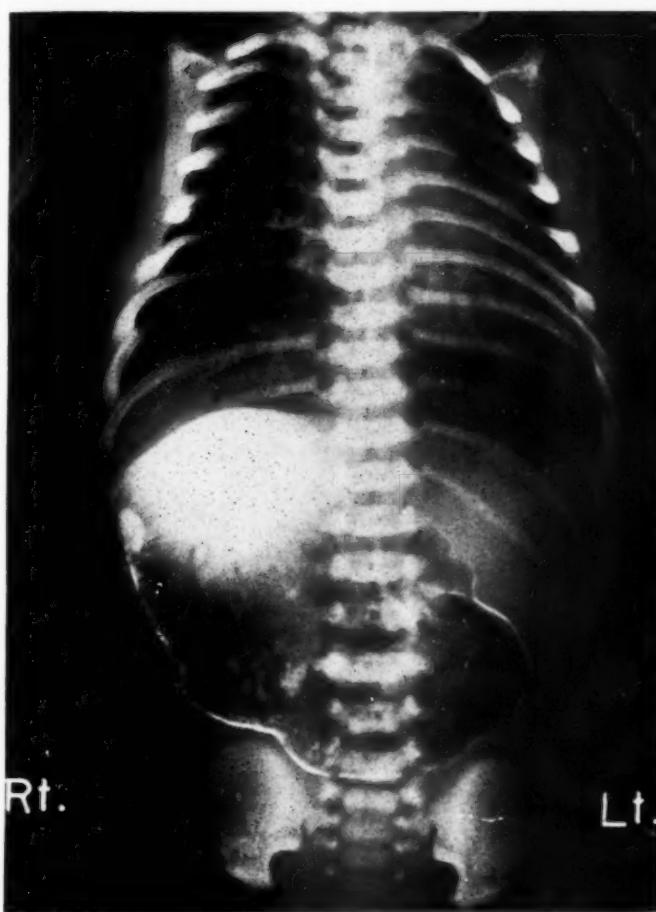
Posteroanterior roentgenogram of the chest and abdomen. Heart is enlarged with apex toward the left. The stomach is markedly dilated with no gas or barium entering the duodenum.
